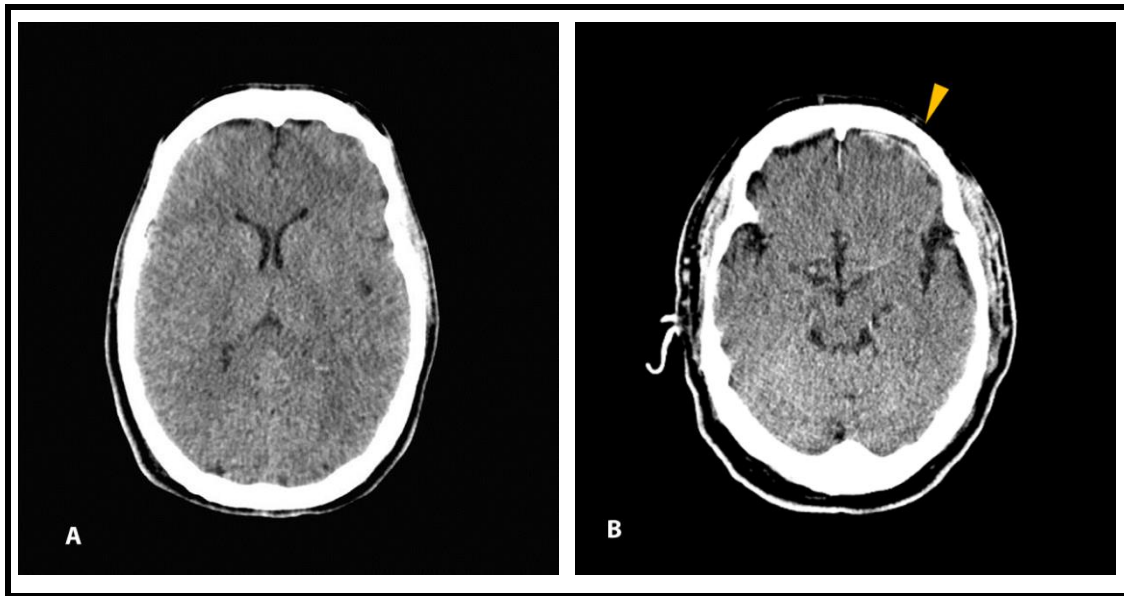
Examples of CT scan results in TBI and their corresponding severity score on the Marshall classification scale. In image A, normal CT scan findings (Diffuse injury, Grade I) observed in a 19-year old patient at 3 hours after a moderate TBI (initial GCS score of 10), after being involved in a road traffic accident and ejected 4m away from the passenger seat through the windshield. In image B, a small contusion is visible in the right frontal lobe (arrowhead, Diffuse injury, Grade II) of a 69-year old man that had a GCS score of 15 at all time after hitting his head occipitally in a casual ground-level fall. GCS: Glasgow Coma Scale; TBI: traumatic brain injury.
